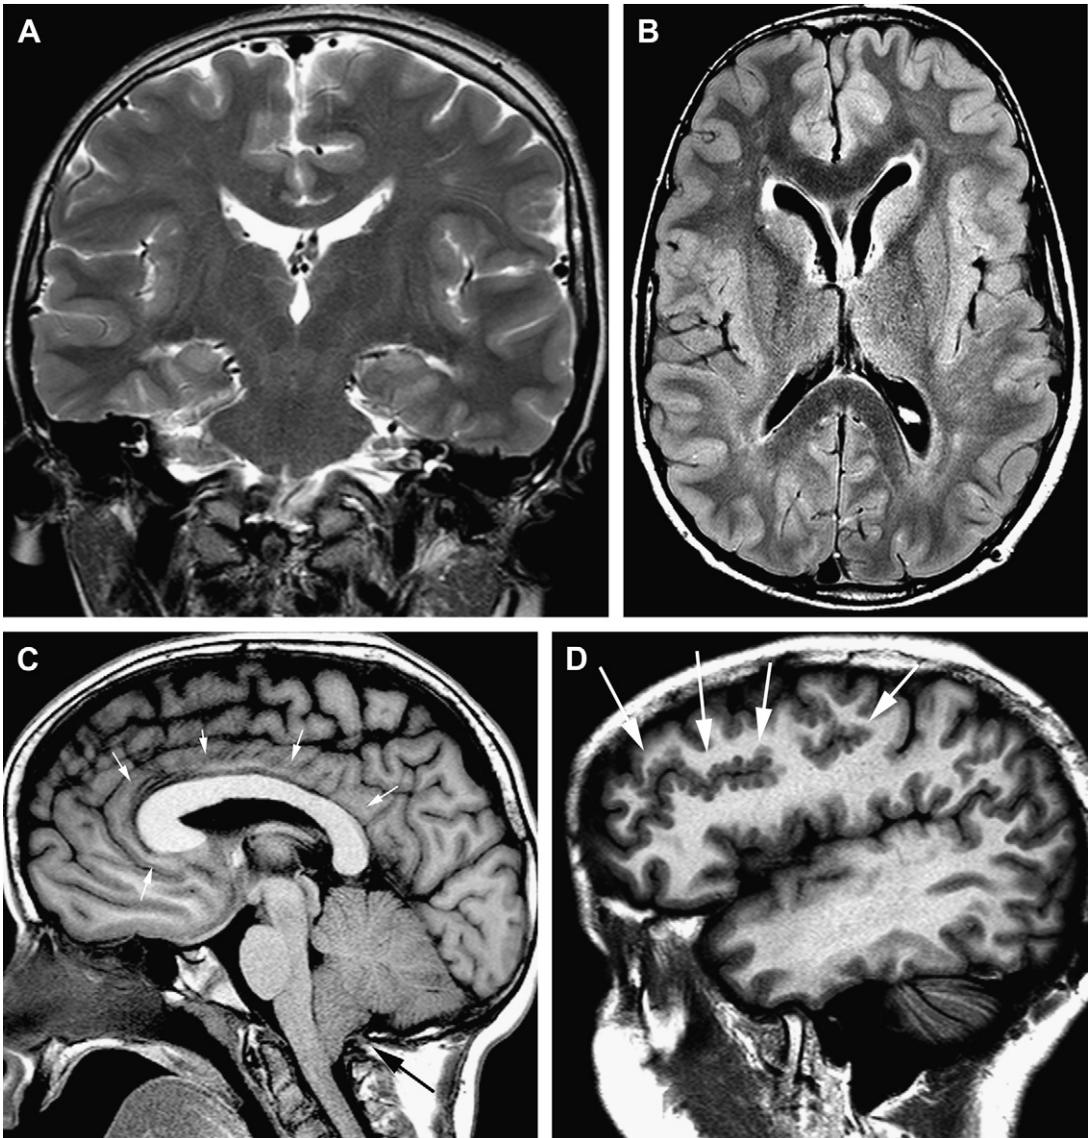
Left HME, Proteus syndrome. (A) Coronal T2. Mild hypertrophy of left hemisphere with dysplasia of the mesial temporal lobe; prominent and ill-shaped ventricles bilaterally. (B) Axial FLAIR. Heterogeneous signal in the white matter and periventricular bright signals, bilaterally; note a prominent vessel in the scalp over the left parietal area. (C) Midline sagittal T1 demonstrates prominent corpus callosum (*white arrows*) and a Chiari I deformity (*black arrow*). (D) Left lateral sagittal cut demonstrates a "curly," polymicrogyric appearance of the cortex (*white arrows*) along the otherwise normally located inferior frontal gyrus.
